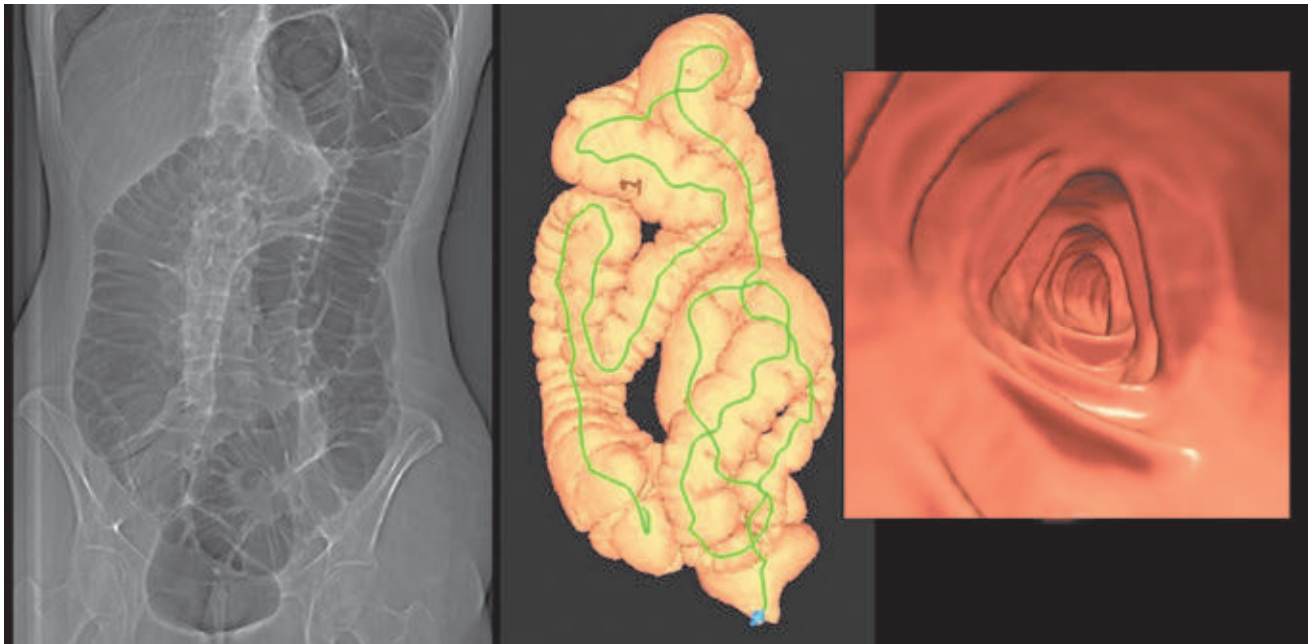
Virtual colonoscopy. A high-resolution contrast CT image of the colon is produced. The mucosa of the colon is highlighted by the contrast medium (*left*). A computer reconstruction of the entire colon in three dimensions is produced. The green line traces the center of the colon (*center*). The radiologist can “fly through” the colon and examine the mucosal surface of the interior (*right*).
